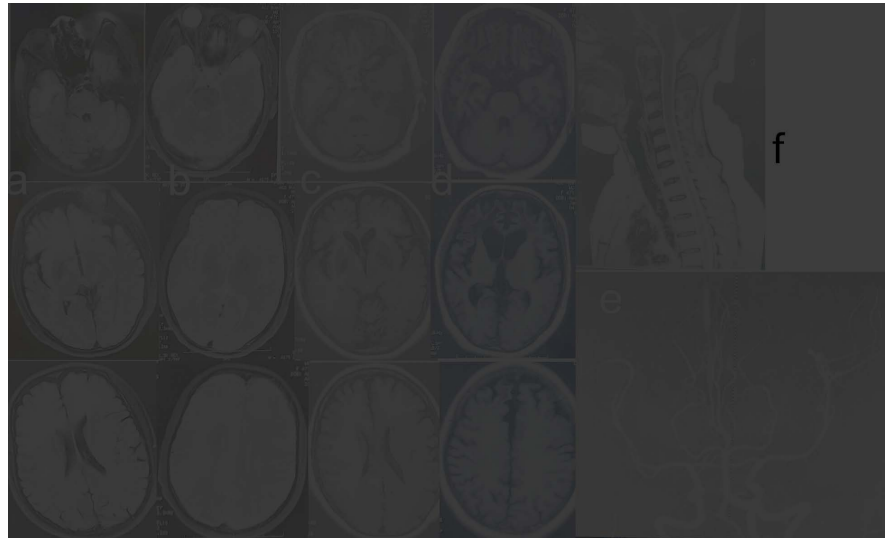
Magnetic resonance imaging (MRI) T2/T2 fluid-attenuated inversion recovery in the course of the disease. Seven months prior, the patient had emotional changes and limb fatigue. MRI shows the bilateral frontal lobes, corpus callosum, basal ganglia, paraventricular nucleus, and right temporal lobe (a). Six months before admission for rehabilitation, a multifocal leukoencephalopathy diagnosis showed that the lesion was larger (b). Five months before rehabilitation, the lesion was stable, but brain atrophy had occurred (c). After admission, brain atrophy was more significant (d). Cranial magnetic resonance angiography showed no significant signs of arteritis (e), and no abnormal signal was found in the cervicothoracic cord (f).
